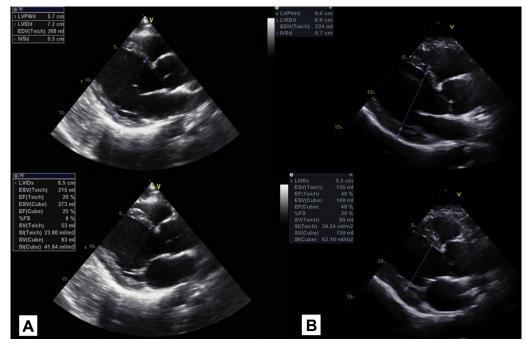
Echocardiogram parasternal long-axis views with left ventricular internal diameter end-diastole (LVIDd) and end-systole (LVIDs), pre (A) and post (B) cardiac contractility modulation implantation.
